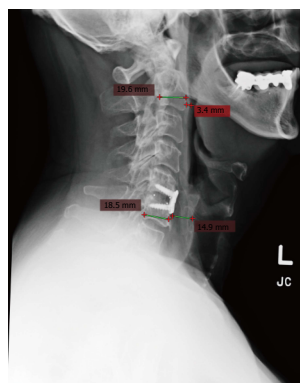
Plain lateral radiograph of the cervical spine, taken one week postoperatively, which shows the normal dimensions of the prevertebral space being less than 50% of the vertebral body at C2 and less than the body width of C6 respectively.
